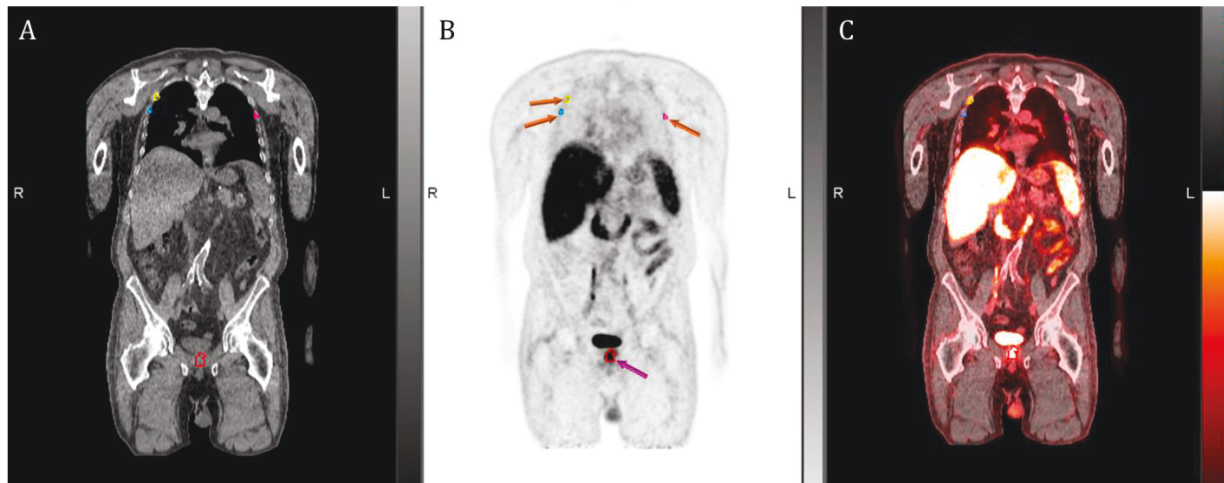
An example of a [^{18}F]DCFPyL PET/CT image. “A” shows a coronal CT slice, “B” shows the corresponding PET slice, and “C” shows the fused PET/CT. Primary lesion in prostate gland is shown by a purple arrow in “B”, and three metastatic lesions in ribs are shown with orange arrows.
